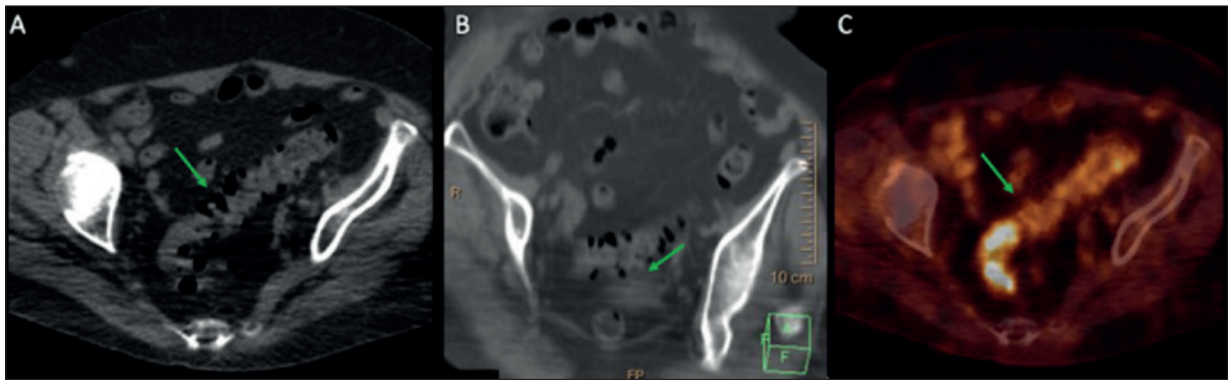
Incidental finding in a 76-year-old multiple myeloma patient who underwent [^{18}F]FDG-PET/CT for post-therapy (chemotherapy, zoledronic acid and immunosuppressive therapy) restaging. Diverticular disease (green arrows) was detected on co-registered CT (A, axial and B, oblique reconstructions), and classified as nM3-IF, because of a wall thickening, an irregular hyperdensity of perivisceral fat and a small peritoneal effusion were observed. This finding showed mild [^{18}F]FDG-uptake on (C) axial fused PET/CT image.
